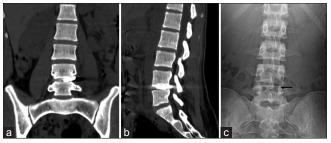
The bullet lodged at L4-5 disk space in coronal (a) and sagittal (b) CT scan, and postoperative a unilateral L4-5 partial hemilaminactomy defect (black arrow) on the left side (c) after removal of bullet
